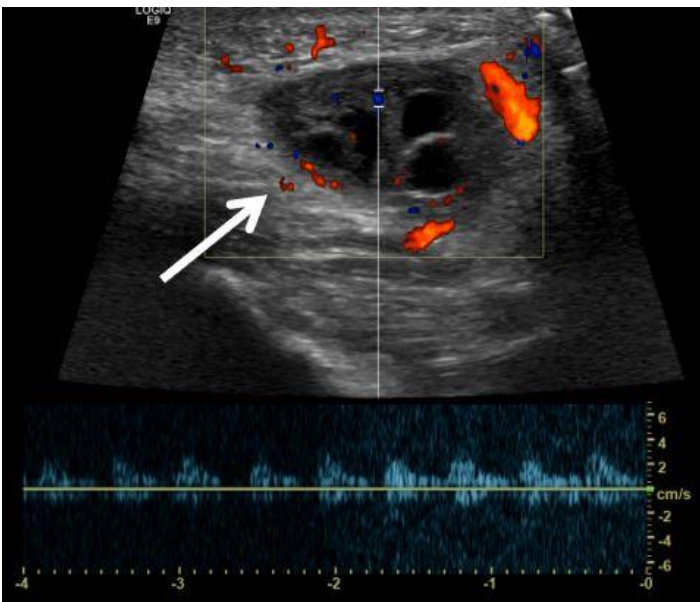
Ultrasonography with Doppler showing an incarcerated ovary (arrow) within an inguinal hernia.
